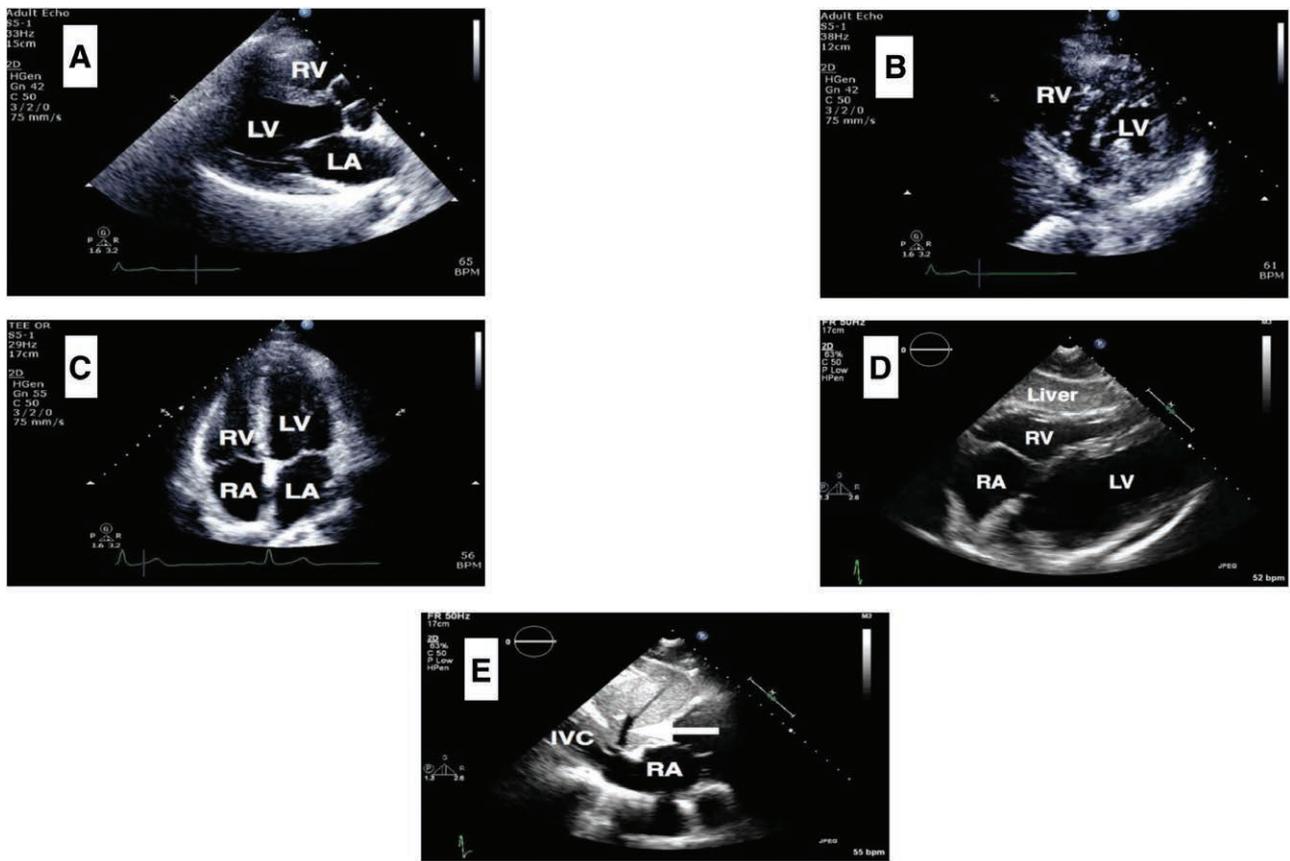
Composition of FoCUS examination. A, Parasternal long axis view. B, Parasternal short axis view. C, Apical 4-chamber view. D, Subcostal 4-chamber view. E, Subcostal inferior vena cava view.
